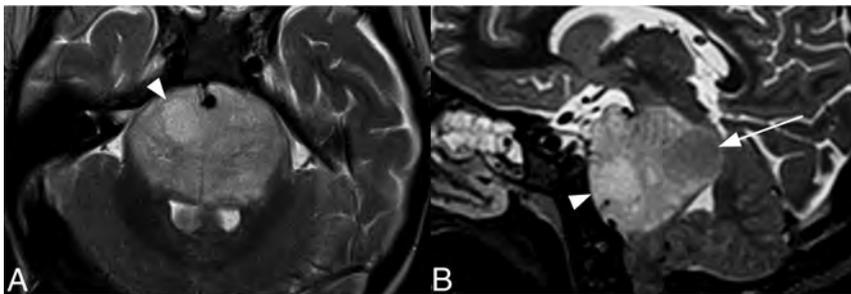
Axial (A) and sagittal (B) T2-weighted MR images of a DIPG with both non-necrotic $T2^{HrF}$ (arrowhead) and $T2_{HoF}$ (long arrow).
